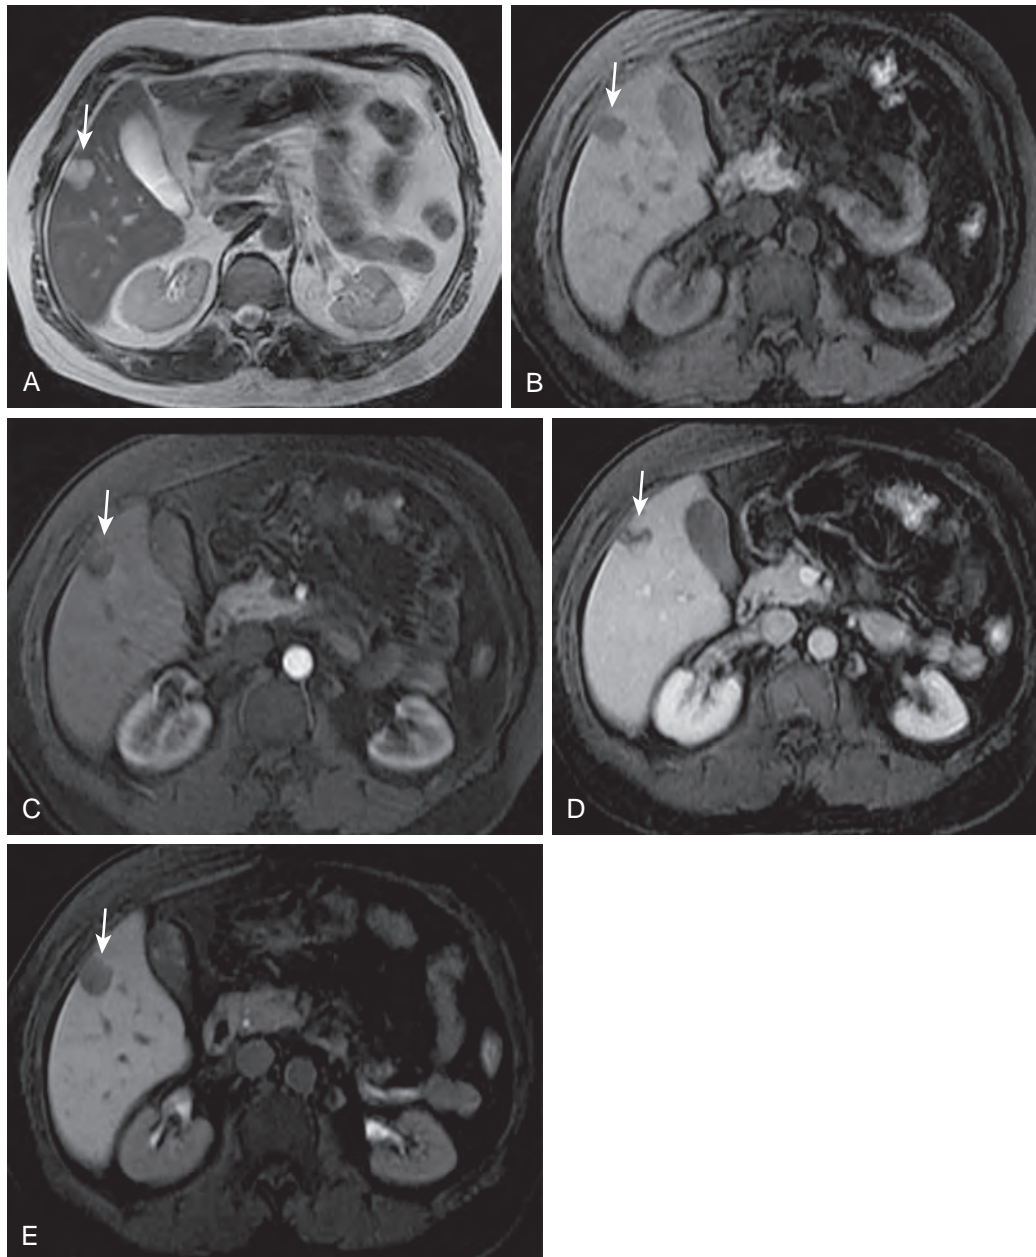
Hepatic hemangioma: MRI features. A patient with a typical hemangioma in the right lobe of the liver (arrow). The hemangioma is hyperintense on the T2-weighted image (A) and hypointense on the T1-weighted image (B). It shows progressive nodular enhancement on the arterial phase (C) and late phase (D) images. As expected, it does not show any uptake of the hepatobiliary contrast agent and becomes hypointense on the hepatocellular phase image (E).
